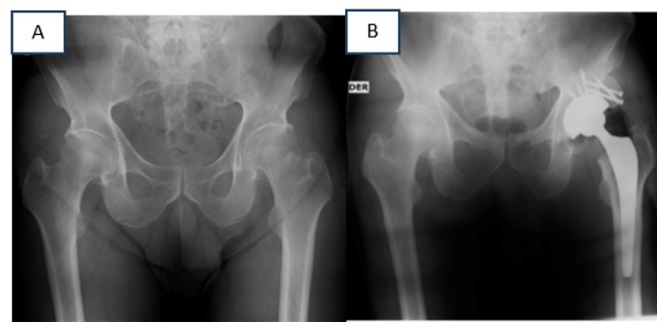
AP radiograph of the patient on admission to the emergency department (A). Postoperative radiograph. Due to the superolateral acetabular defect during reaming, it was decided to reinforce the acetabular cup coverage with a femoral head autograft, which was secured with cancellous bone screws (B).
